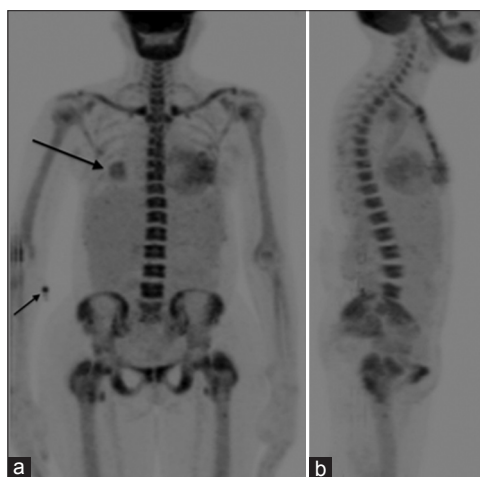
Whole body anterior (a) and lateral (b) maximum intensity projection (MIP) images from 18F fluorodeoxyglucose positron emission tomography/computed tomography (FDG PET/CT) scan demonstrated diffusely increased FDG uptake in the osseous structure without any abnormalities on corresponding CT scan and absence of radiotracer excretion in the kidneys and urinary bladder. Focal radiotracer uptake was observed in the primary neoplasm in the right breast (long arrow). A small focus of increased FDG uptake noted in the right antecubital fossa (short arrow) was at the site of radiopharmaceutical injection
